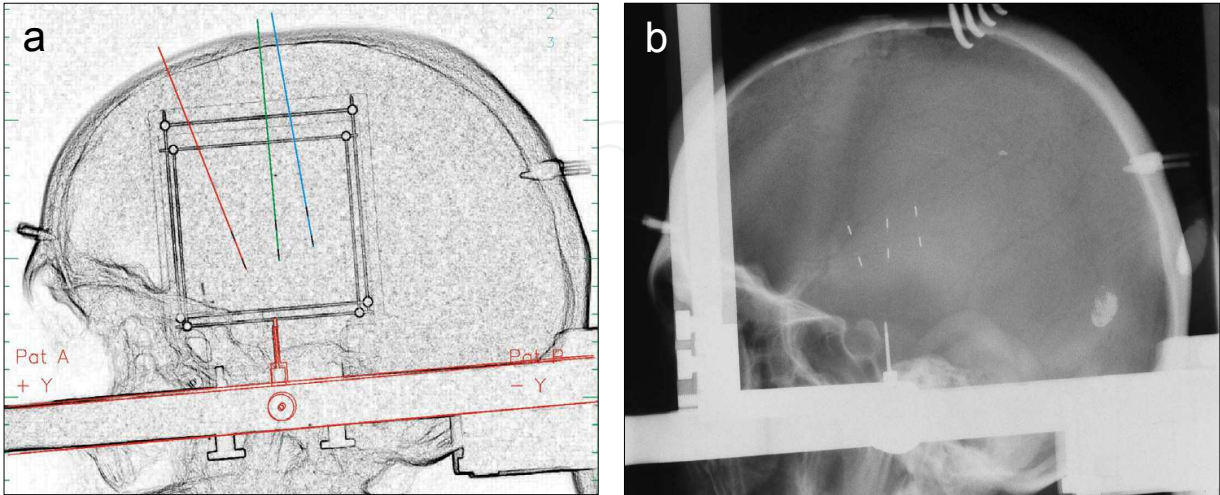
The stereotactic treatment plan. a) Positioning of the catheters and seeds, which is then compared with b) the two plane X-ray images performed after final placement of the seeds-catheters by over-laying.
